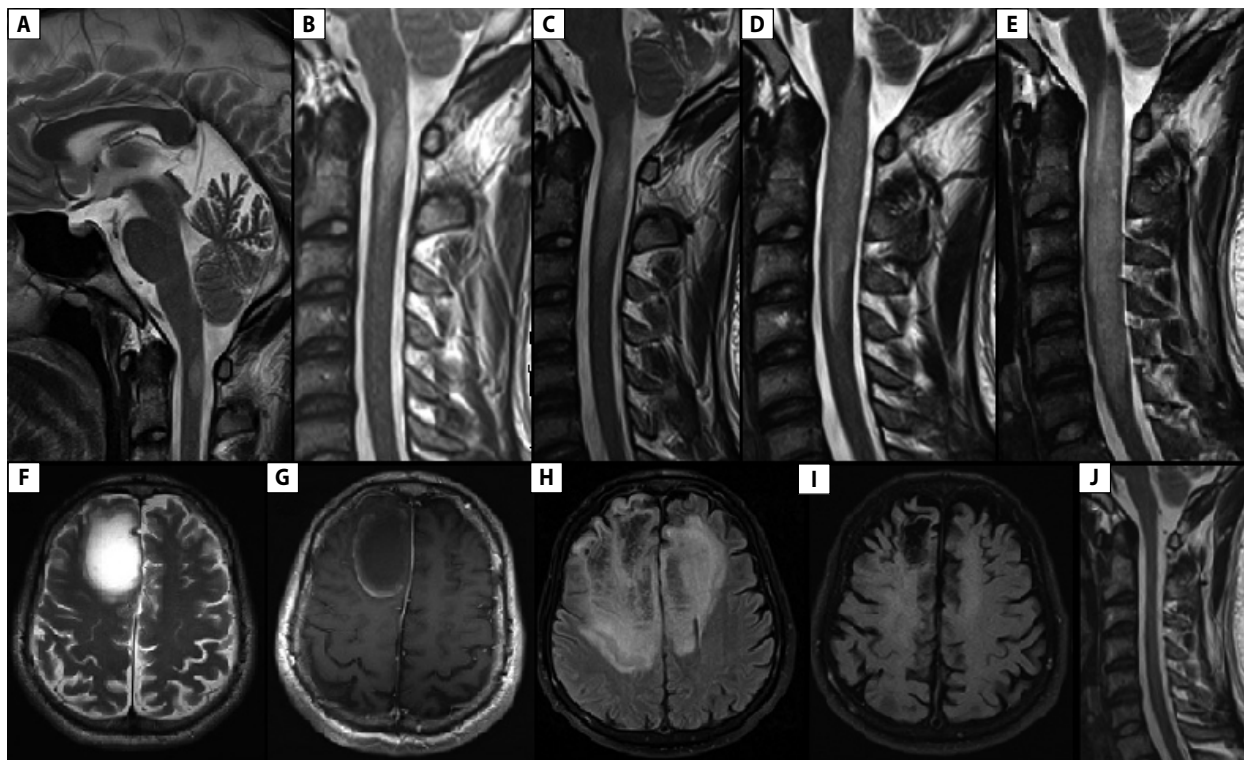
A. T2-weighted sagittal image demonstrating acute phase of transverse myelitis located at C1–2 level; B–D. Lesion progression after five days of high-dose methylprednisolone treatment; E. Lesion progression in longitudinal extensive transverse myelitis between bulbus and C6 level after 10 more days of high-dose methylprednisolone treatment; F. Axial T2-weighted image demonstrating tumefactive demyelinating lesion in right frontal lobe with surrounding vasogenic oedema following rituximab therapy; G. Axial T1-weighted image with open-ring enhancement; H. Axial fluid-attenuated inversion recovery (FLAIR) image demonstrating bifrontal lesion with mass effect; I–J. Follow-up MRI at six months showing significant improvement in cerebral and cervical lesions
